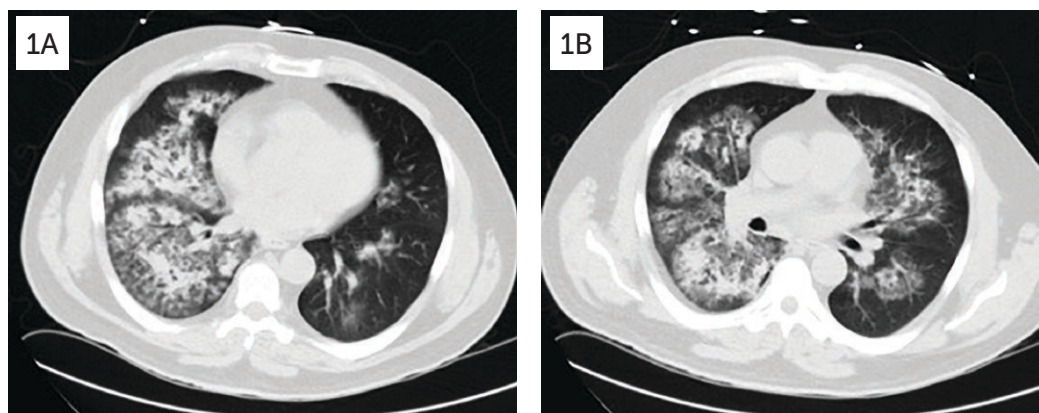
Images from the patient's CT scan of the chest demonstrates multifocal airspace opacities in a peri-bronchovascular distribution with relative sparing of the left lower lobe and subpleural spaces.
